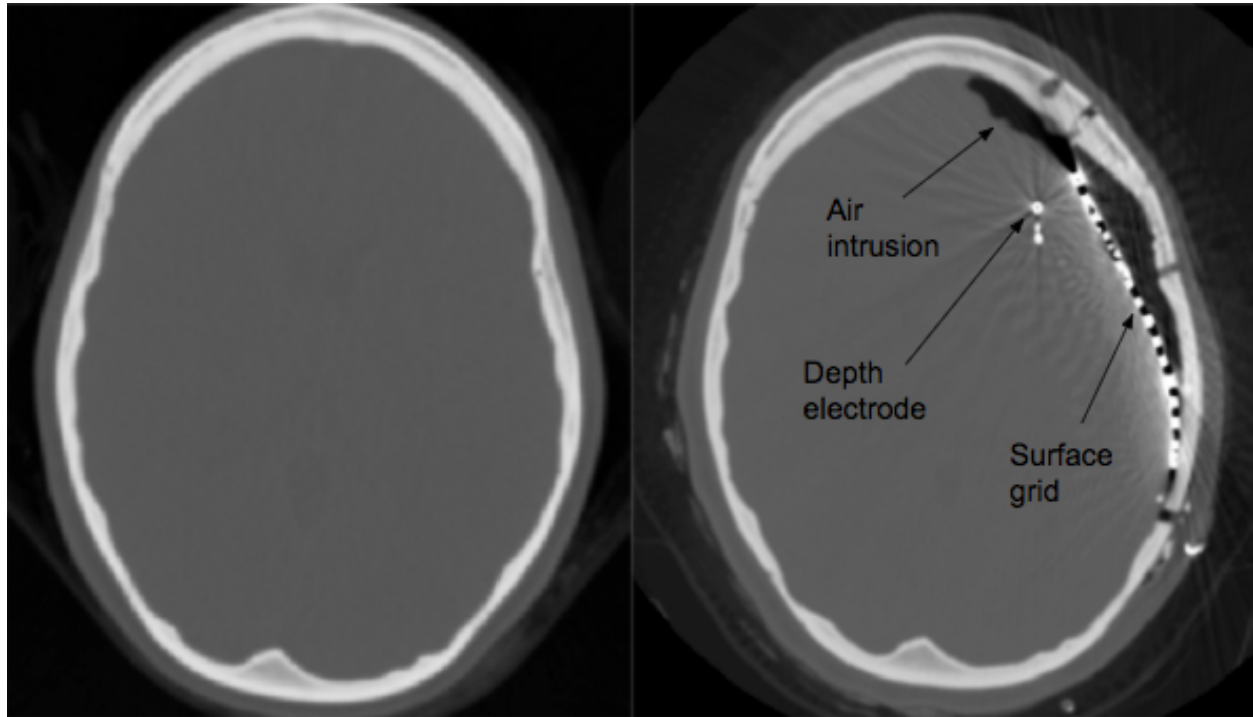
Shift due to electrode implantation and air in the cranial cavity. CT on the left is subject before surgery. CT on the right is the same subject after electrode implantation.
